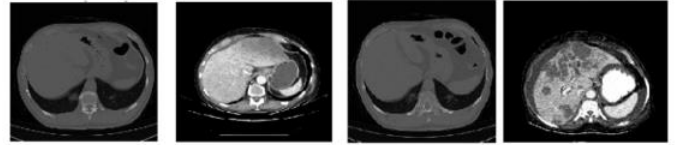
SPIHT reconstructed output corresponding to the abdomen CT data set (ID1 – ID4)
